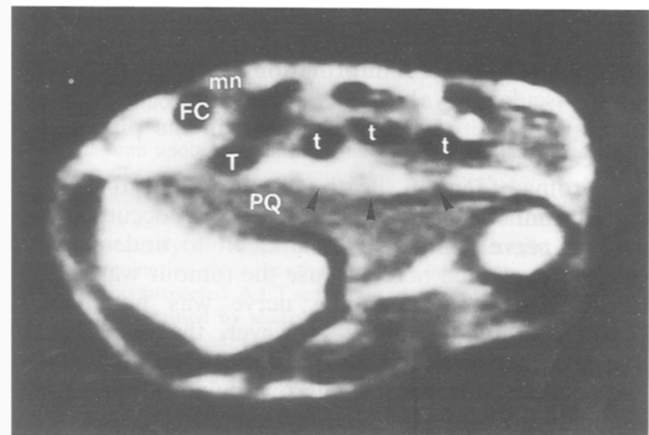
Axial CT scan of the left forearm. The relationship of the mass (curved arrow) and adjacent structures are better characterized (T, tendo M. flexoris pollicis longi; t, tendo M. flexoris digitorum profundus; FC, tendo M. flexoris carpi radialis; mn, median nerve; PQ, M. pronator quadratus).
